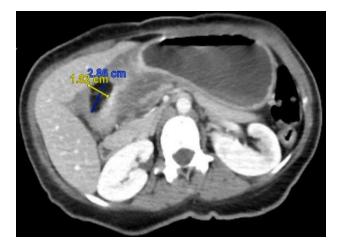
CT scan with axial view showing mass in the antrum and pylorus causing partial obstruction.
